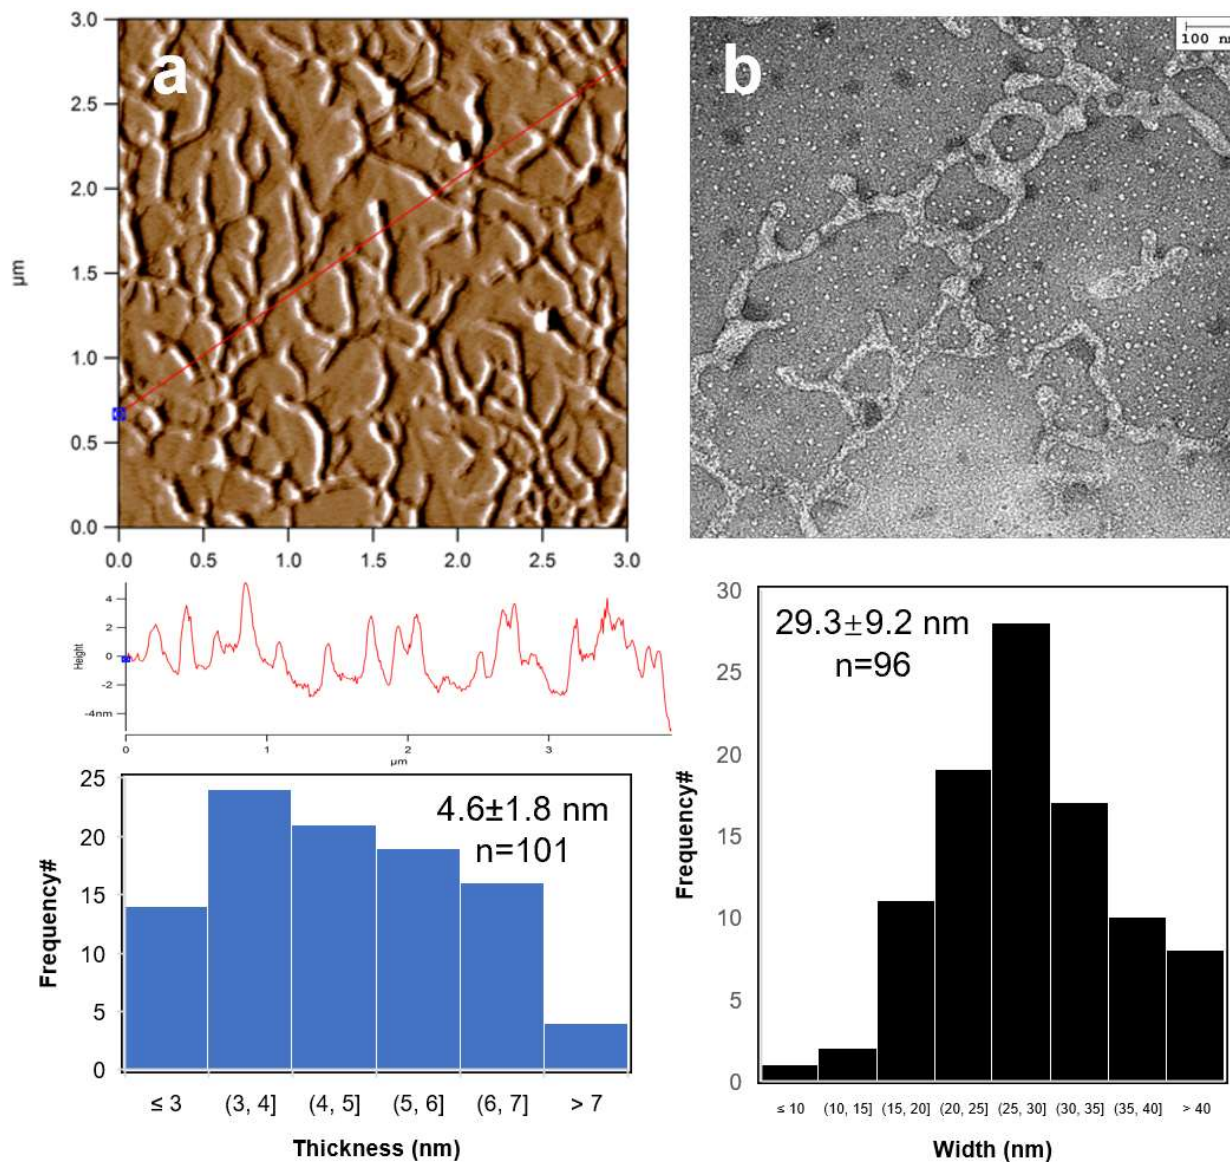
Morphology of Br-CNF3 (0.0005 w/v%, 10 mL) supernatant (5k rpm, 10 min) from ultrasonication (50% amplitude, 30 min): (a) AFM image on graphite, height profile, and height distribution; (b) TEM images on glow-discharged carbon grid with width distribution.
